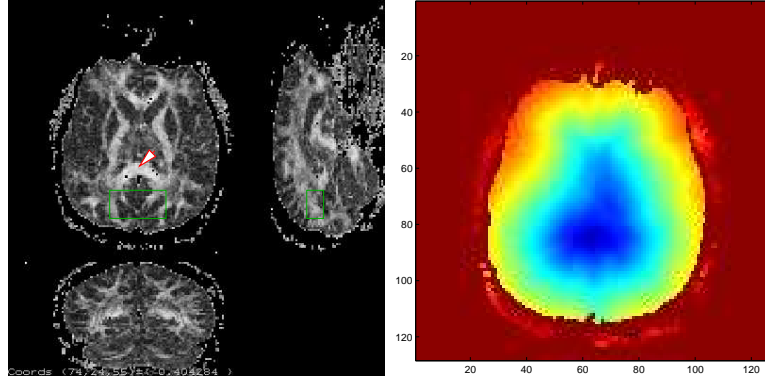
Diffusion tensor MRI data and axial slice of the estimated distance function
